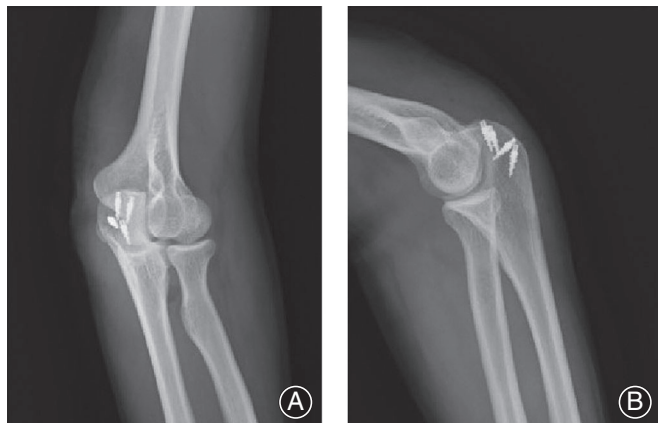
Summary of patient's postoperative status. (A, B) X-ray shows four anchors were placed in the olecranon.
